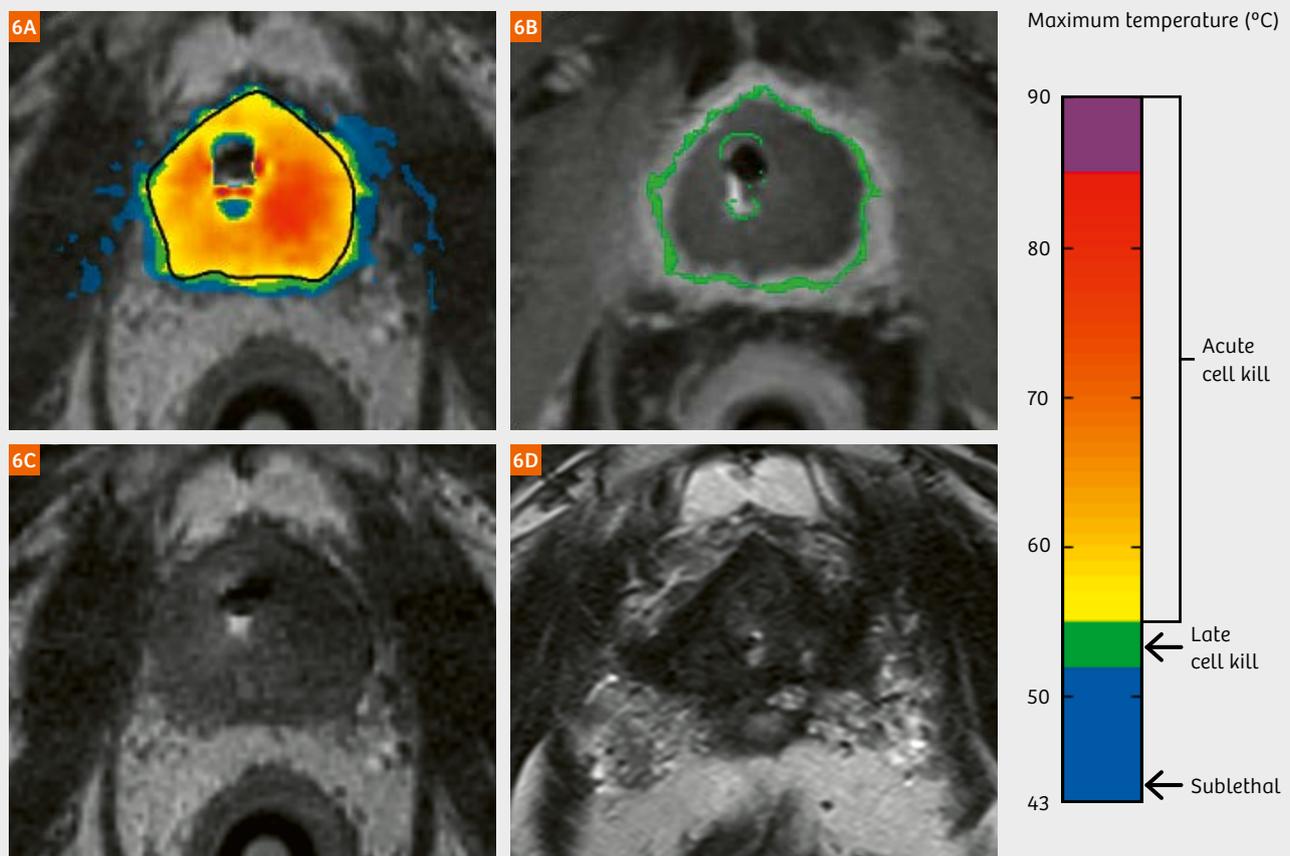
Temporal evolution of a MRI-guided TULSA treatment, completed in one full rotation of the UA.
